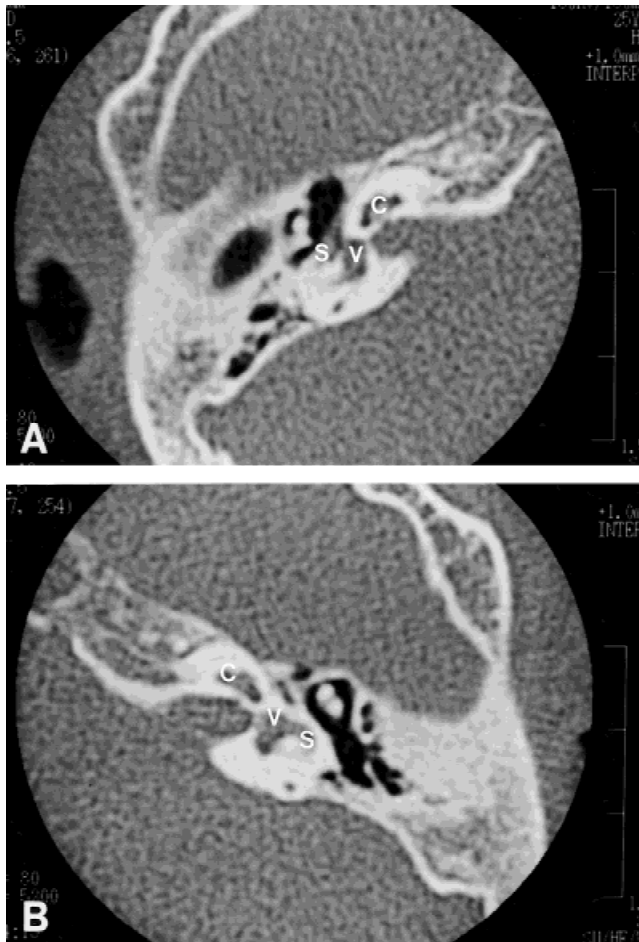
CT of the right (A) and left (B) inner ears of patient 1, showing bilateral Mondini dysplasia: flattened cochleas with only one-half turns (C), saccular dilatation of the vestibules (V), and deformed horizontal semi-circular canals (S).
